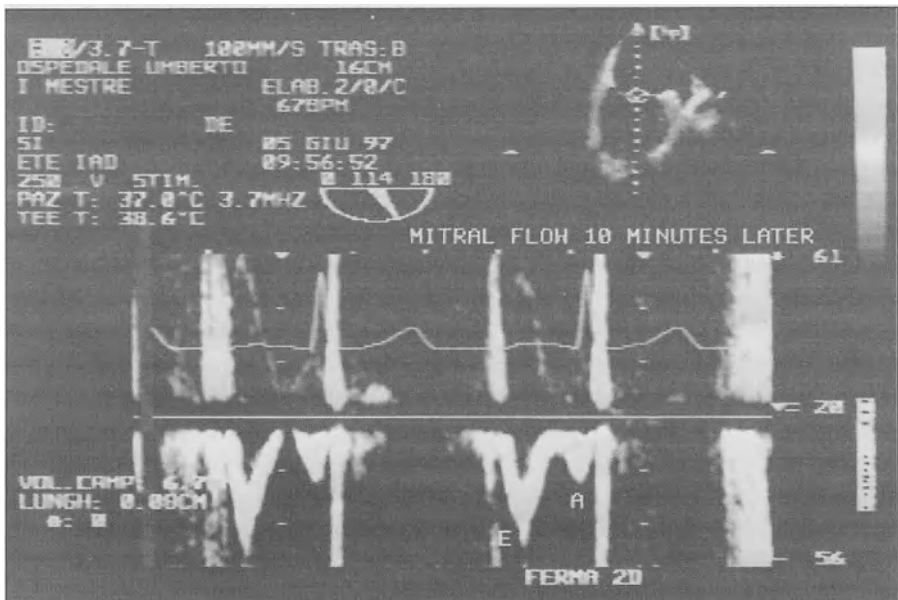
Same Doppler evaluation as in Fig. 3, 10 minutes later: an increase of flow velocity during left atrial contraction as expression of a rapid recovery of atrial mechanical function after IAD is well visualized
